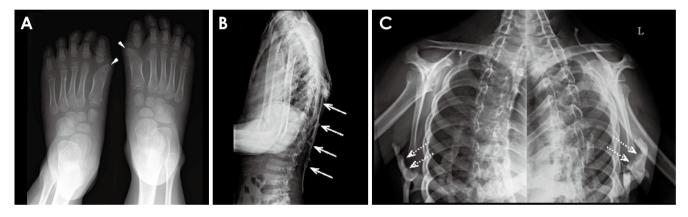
A. A bilateral weight-bearing dorsoplantar radiograph displays hallux valgus on both sides (arrowhead). B. A lateral neutral radiographic view of the thoracolumbar spine reveals heterotopic ossification of the latissimus dorsi muscle (arrow). C. Bilateral scapular anteroposterior radiographs show heterotopic ossifications at the proximal humerus and chest wall (open arrow).
